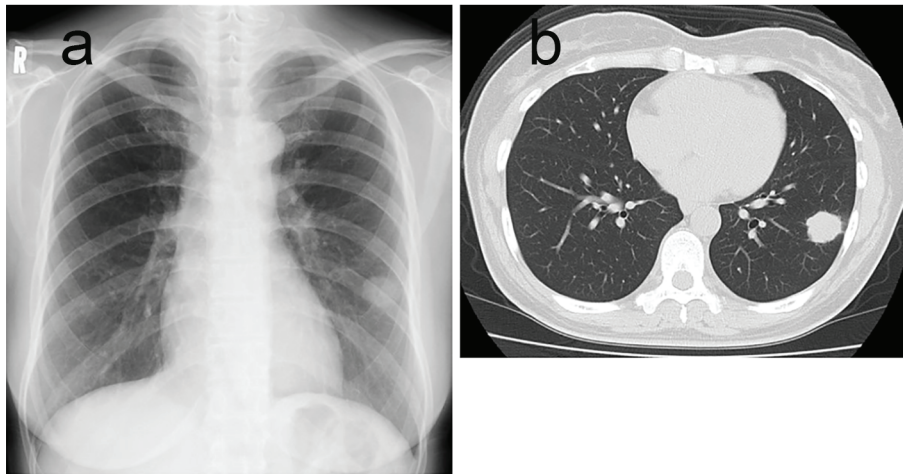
Preoperative chest X-ray showing a 2.5-cm round shadow in the left lung (a). CT revealed spicula and pleural indentation in S6 (b).
